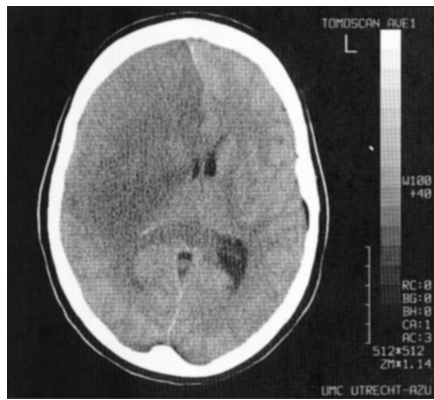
Computed tomographic scan of a 32-yr-old patient with a large infarct in the territory of the right anterior and middle cerebral arteries, accompanied by space-occupying edema and midline shift, 1 day after the onset of symptoms.
